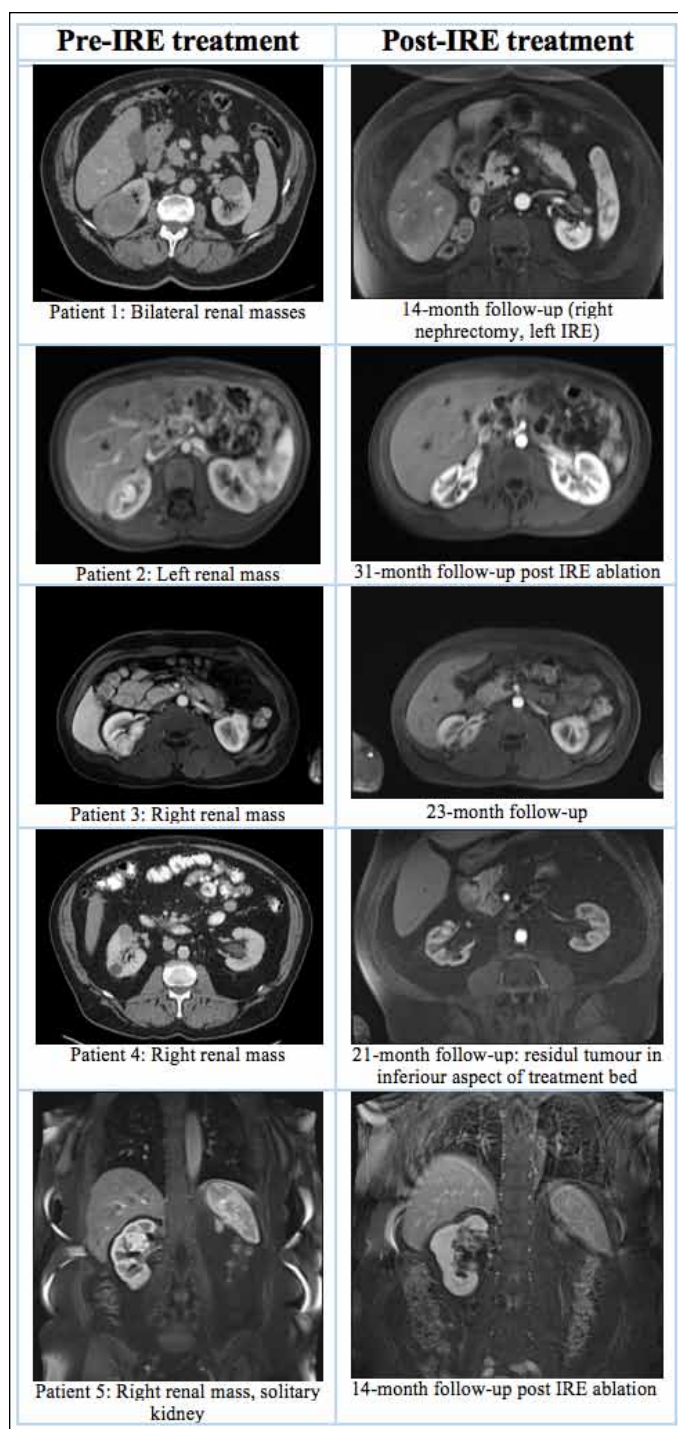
Magnetic resonance and computed tomography images of all patients pre- and post- irreversible electroporation (IRE) ablation. Only one patient had residual tumor at followup.
